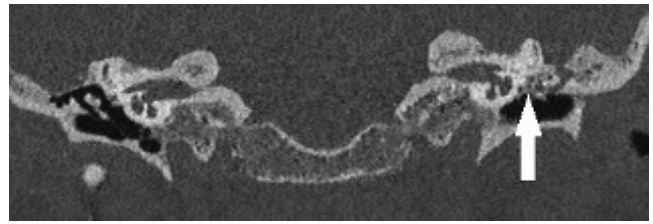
Coronal CT showing diffuse ossification (tympanosclerosis) in the medial left epitympanum (arrow) with adjacent chronic effusion. Note the normal right epitympanum.
